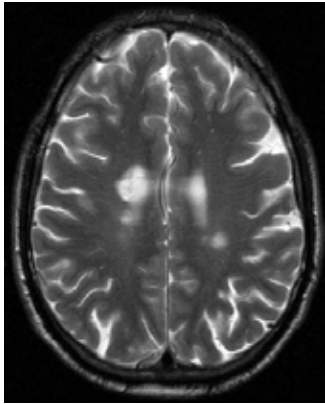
Sample brain MR image with MS lesion
